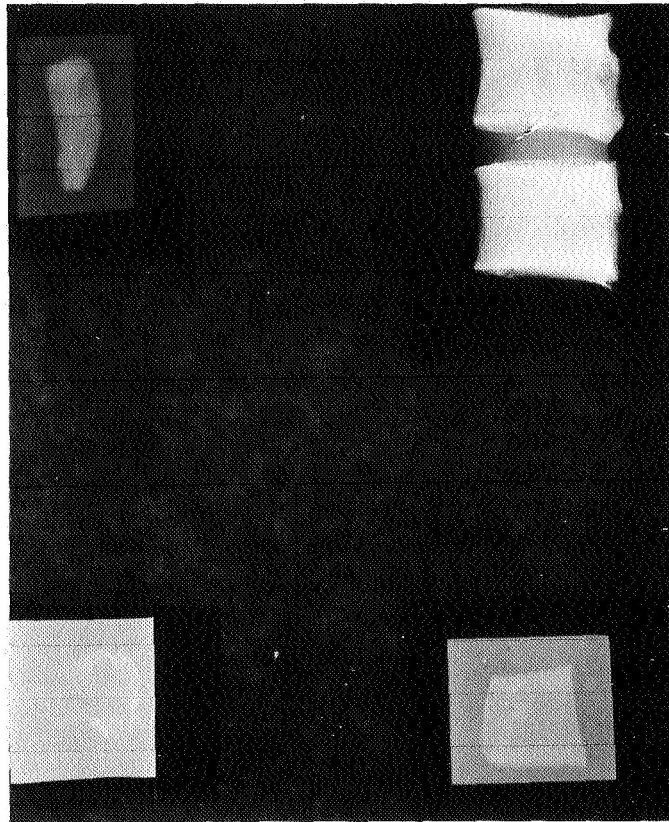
Radiographs showing a four-organ preparation from a nonosteoporotic autopsy subject, male, age 67. The tissue in the upper left is skin; lower left, fascia; upper right, first and second lumbar vertebrae; lower right, aorta. Samples of tissue from the four organs were analyzed for total calcium, total phosphorus, hexosamine, and collagen in an effort to determine whether mineral was transferred from bone to soft tissue in patients with osteoporosis. The results on approximately 39 consecutive autopsy subjects were equivocal.
